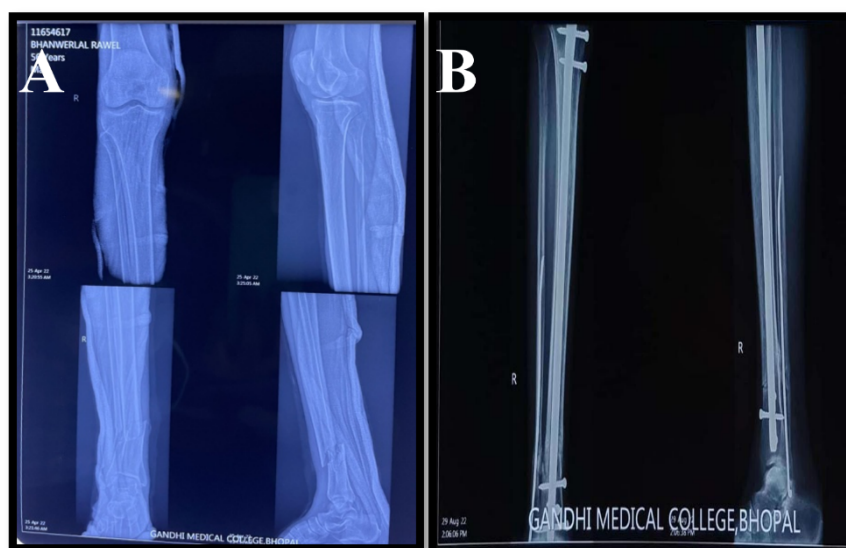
A and B showing preoperative Xray and post operative x ray after 4 months respectively
